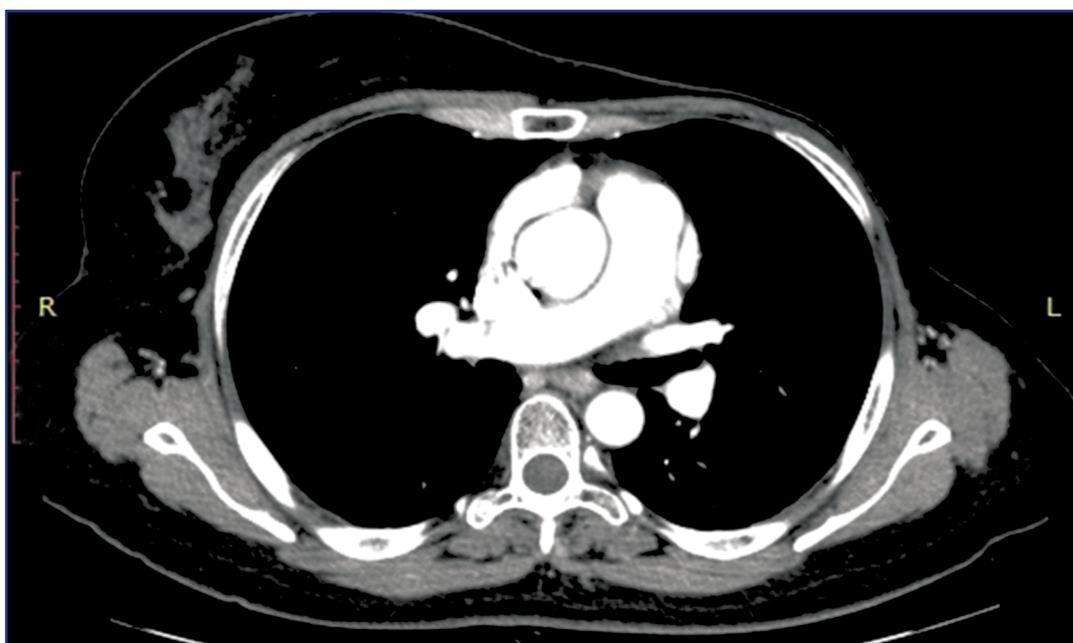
Thoracic Region CT with bolus contrast from June 2019. Complete regression of the metastatic lesion of the right breast.
